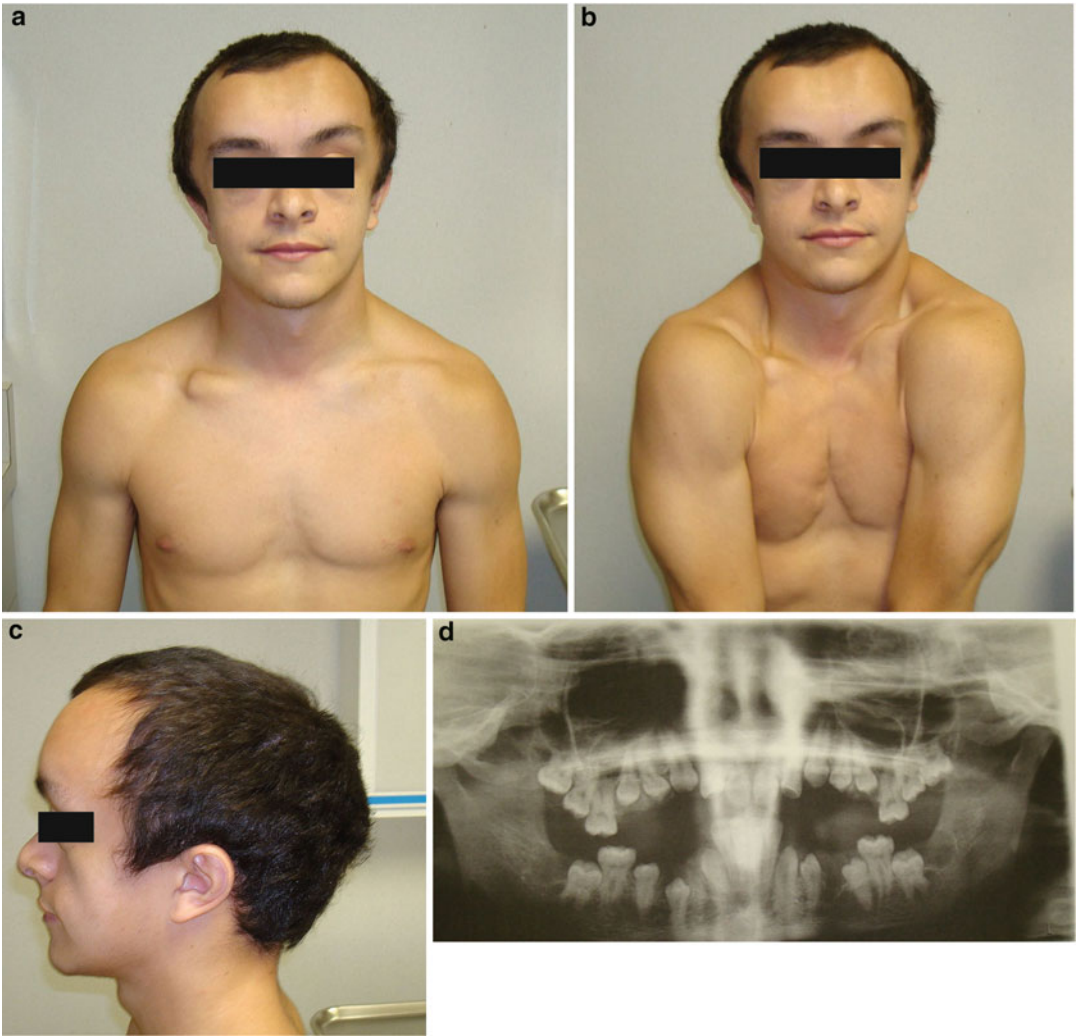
(a–d) Another adult patient with cleidocranial dysplasia, showing typical clinical and dental features (radiograph)
